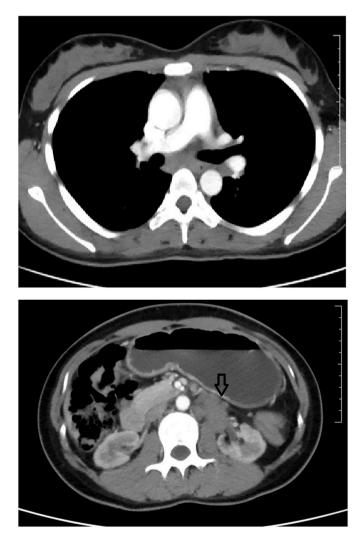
(a)CT chest showing subcarinal lymphnode from where EBUS TBNA was taken. (b) showing para vertebral mass lesion adjacent to left kidney.
